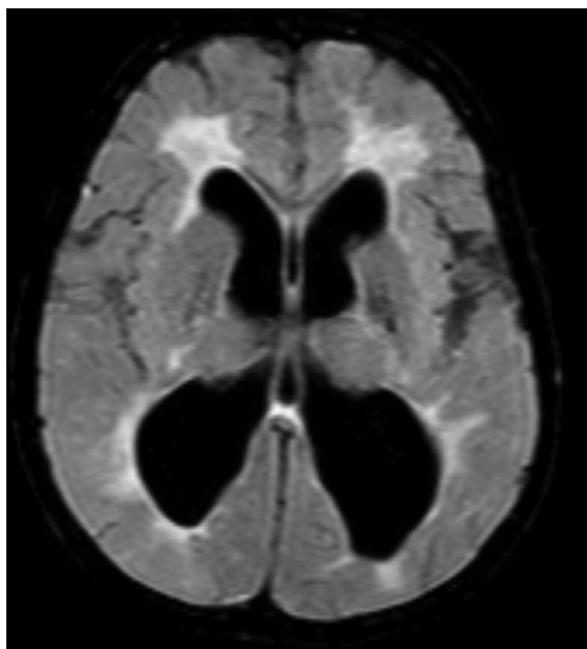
MRI at age 16 revealed significant white matter abnormalities as well as cerebral and cerebellar atrophy in the setting of microcephaly.
